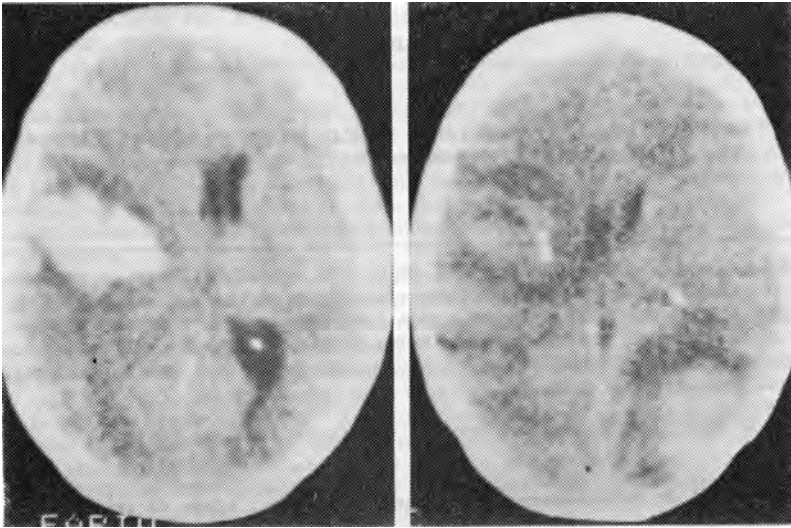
(left). A noncontrast CT scan shows intracranial hemorrhage in the left temporoparietal area.
